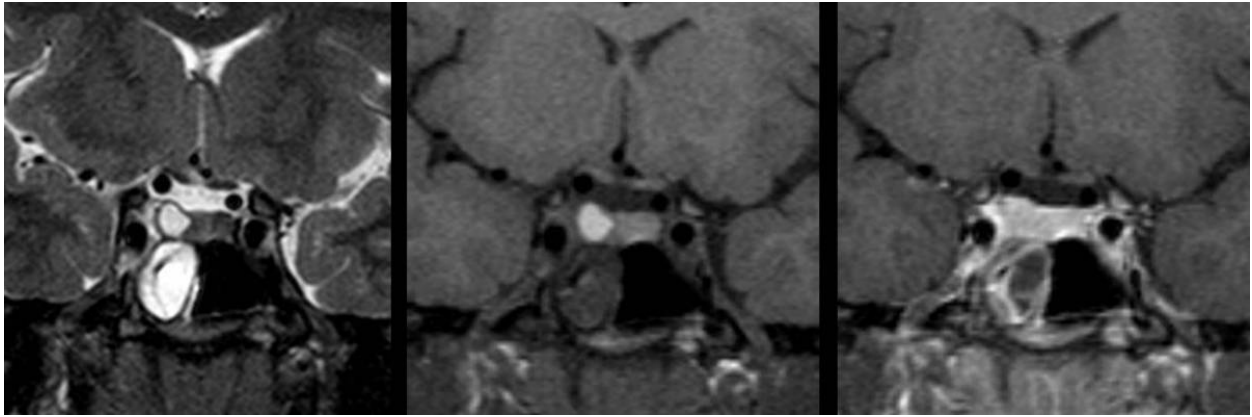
21 y/o female with Rathke cleft cyst. MRI images. From left to right T2, T1 and T1+G.
